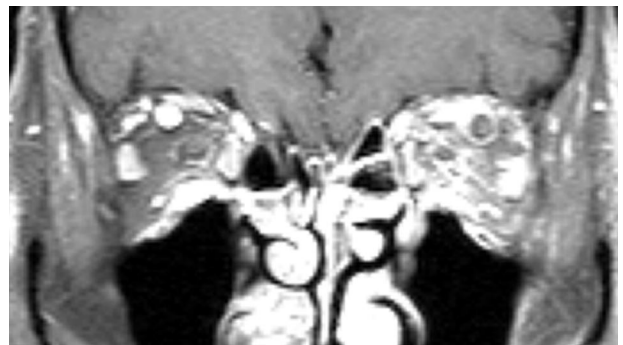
MRI with gadolinium contrast and fat suppression showing a low-intensity signal within the left superior ophthalmic vein.
